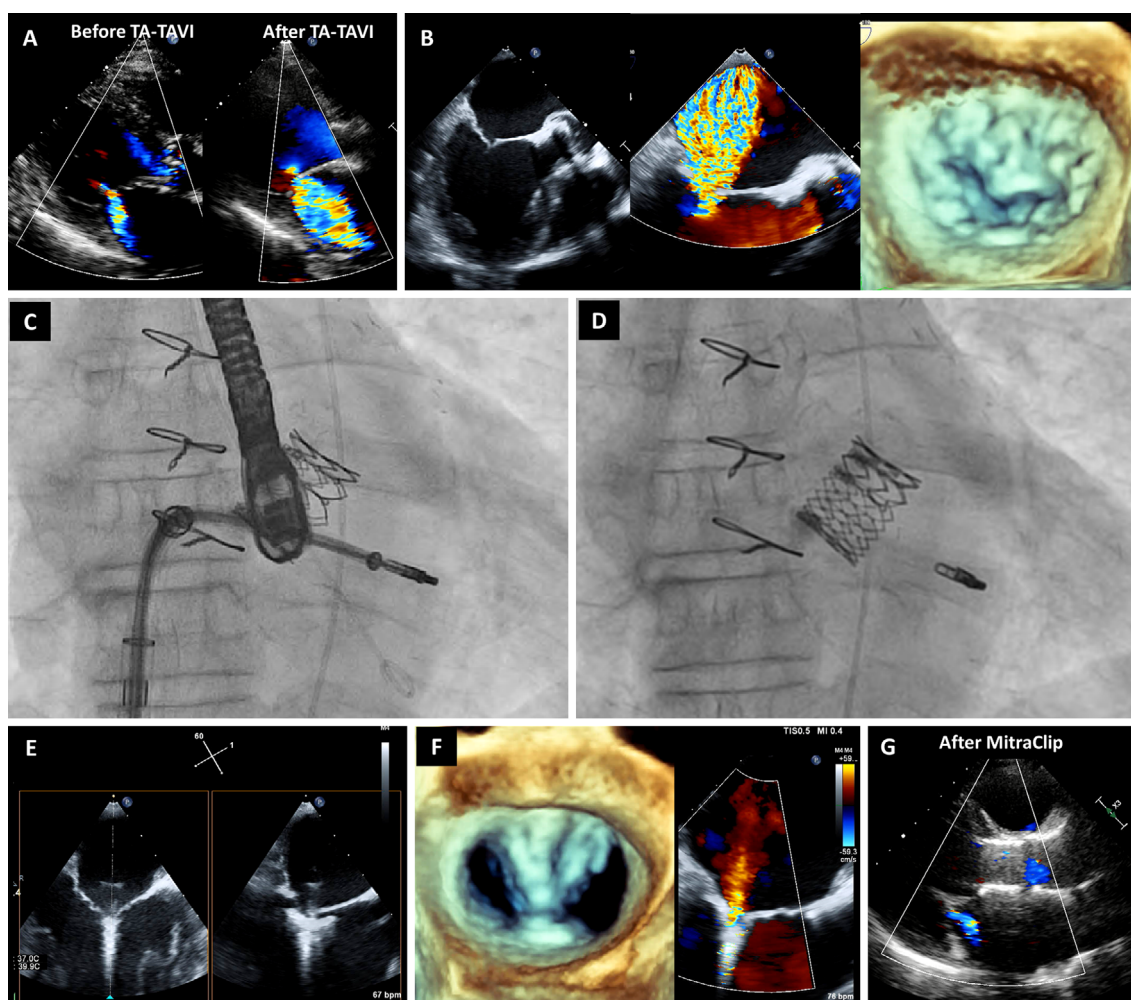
(A) Transthoracic echocardiography showed the worsening of mitral regurgitation after transcatheter aortic valve implantation (TA-TAVI). (B) Transesophageal echocardiography showed decreased coaptation of the mitral valve without leaflet prolapse or chordal rupture. (C-E) A MitraClip[®] system was delivered via the right femoral vein by a transseptal approach and was successfully deployed. (F-G) 3D and color Doppler echocardiography after MitraClip[®] deployment. Mitral regurgitation was successfully reduced to grade 1+.
